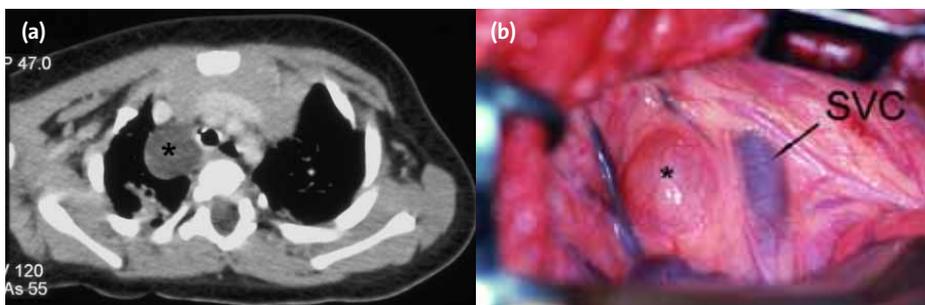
Bronchogenic cyst adjacent to the trachea on CT scan (*) (a) and in another case, a bronchogenic cyst (*) adjacent to the superior vena cava (SVC) at thoracotomy (b).
